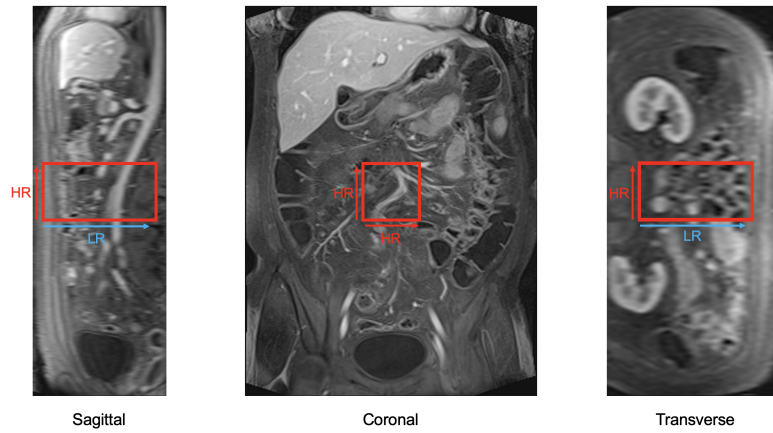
An example of an image from a 3D anisotropic MRI acquisition. In this example, two directions have high spatial resolution ($\approx 1\text{mm}$), while the third direction (shown in both the Sagittal and Transverse view) has lower spatial resolution ($\approx 6\text{mm}$).
